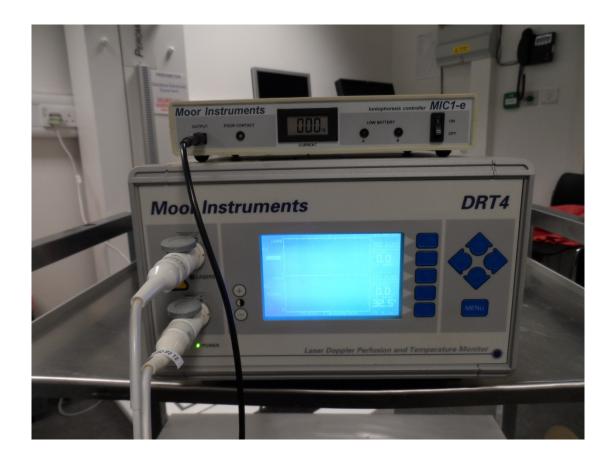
Laser Doppler flowmeter utilised in conjunction with an iontophoresis controller
